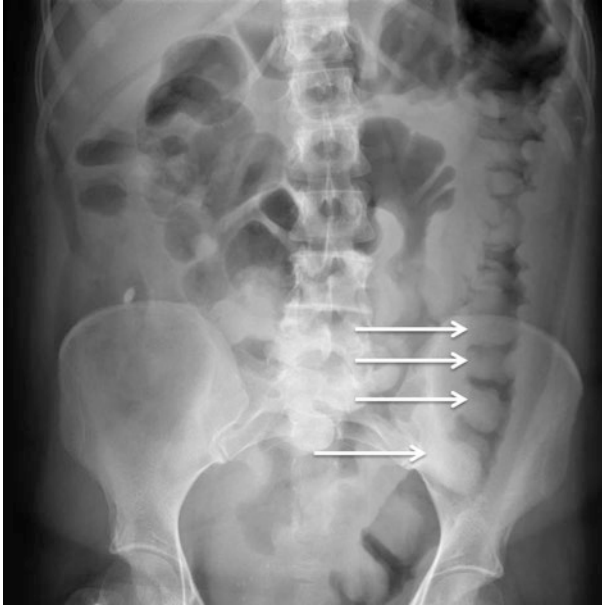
Abdominal radiograph demonstrating ‘thumbprinting’/thumb-like indentations in the large bowel (solid arrows) due to haustral oedema in a patient with acute colitis
